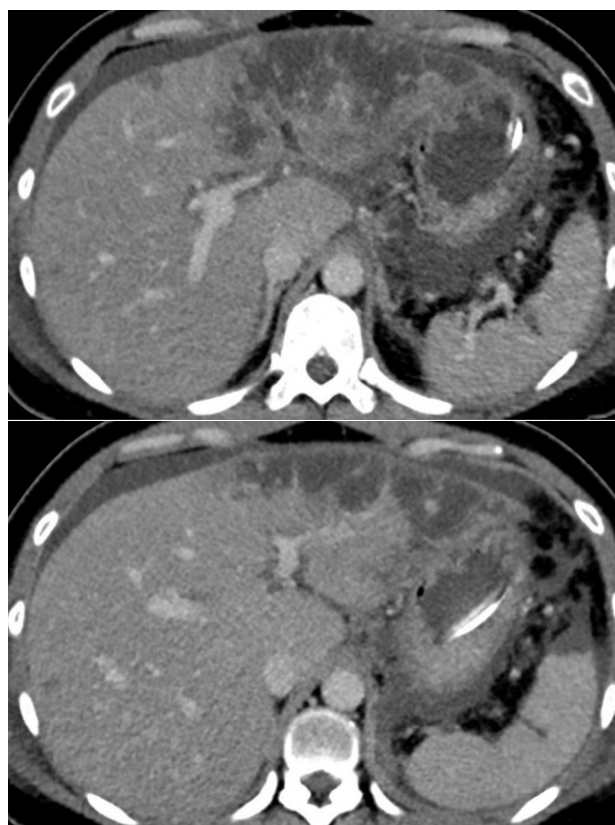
Course of the hypoperfused area on contrast-enhanced CT imaging performed on day 8 after admission. The left portal vein is less narrowed, with an improved extent of hypoenhancement in the left liver lobe, although persistent areas of hypoenhancement suggest ischemia/infarction.
